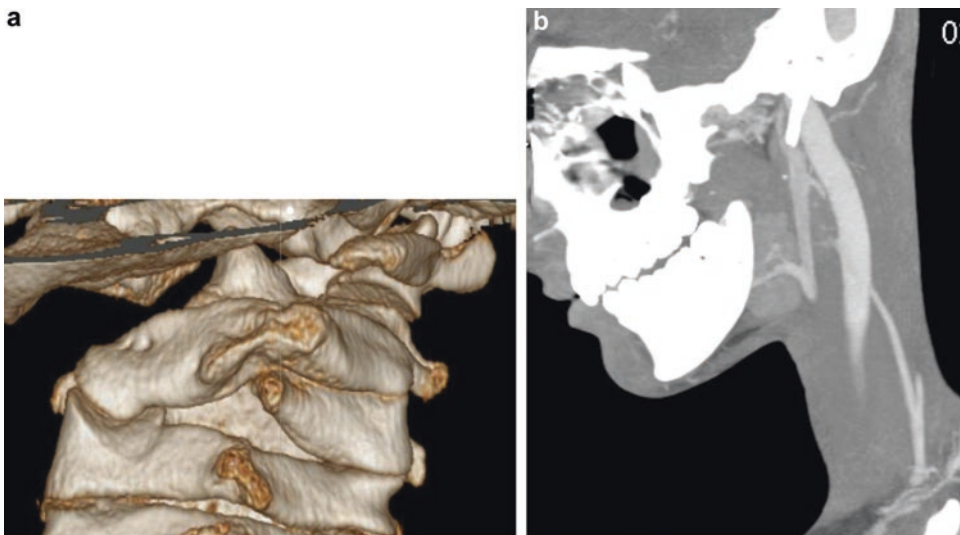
(a) Three-dimensional CT scan of a 12-year-old boy with a hemivertebrae of C1 and C3 and painful torticollis. (b) A CT angiogram can be performed at the same time to assess vertebral artery course and size
